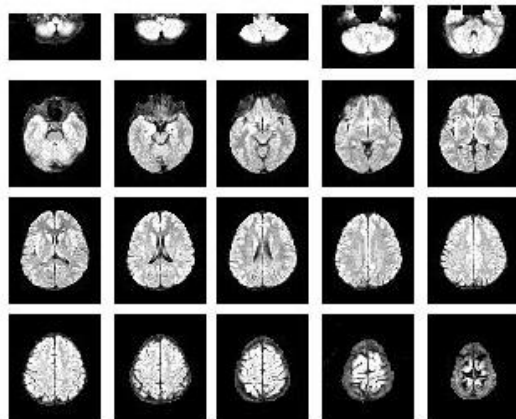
MRI scans post segmentation (Sample 1)
